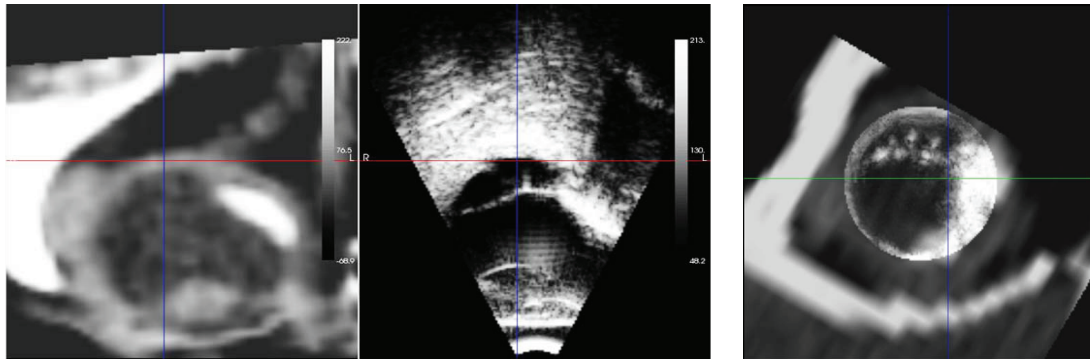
(a) Resampled CT image after applying the object-based transformation, (b) Corresponding US image with cross cursor representing the same spatial location, (c) Fusion of CT and US in the axial direction.
